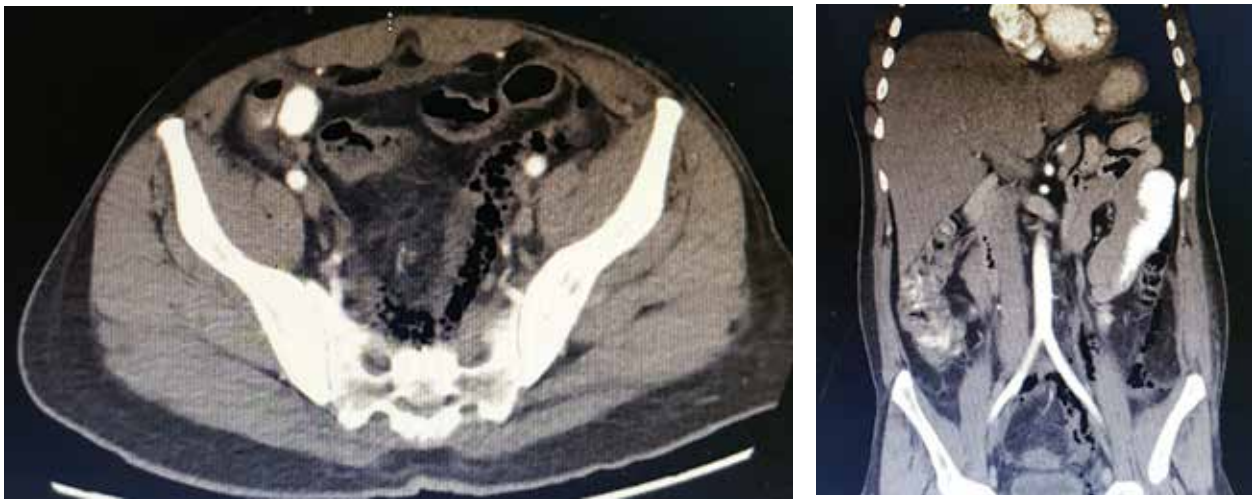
Preoperative CT images showing extensive air in pararectal, presacral, parailiac, pararenal air tracking along left psoas muscle.
